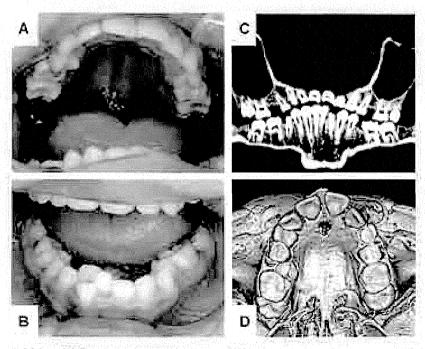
Oral photographs (A,B) and MCCT-synthesized panaramic radiograph (C) of Patient 7 at age of 10 years and MCCT-synthesized upper dental arch of Patient 6 at age of 7 years (O). Note: high palate, malocolosion, small dental erch, excessive tooth wear (A,B), missing upper second premolars on both side and lower left second premolar (C), ectopic tooth eruption of first mulars on both side (O).
